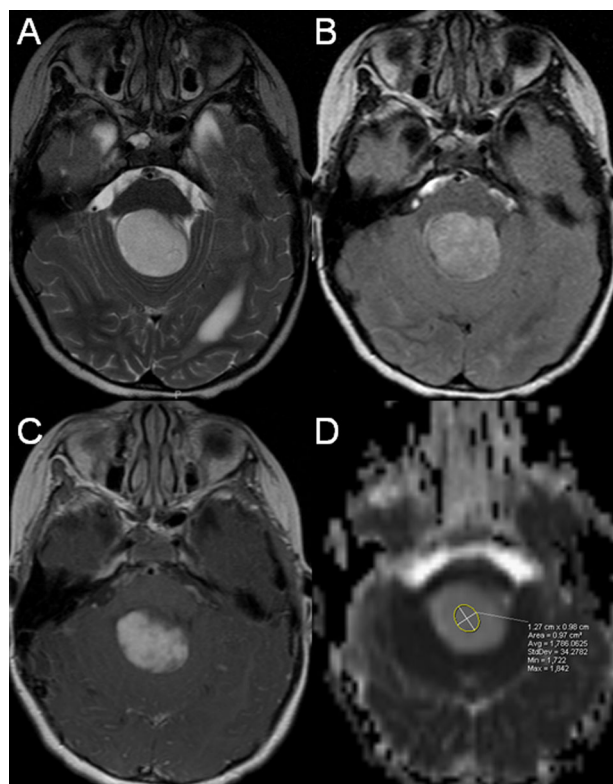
Eleven-year-old female with cerebellar PA. A: Axial T2-weighted and (B) FLAIR images show a large, midline mass with heterogenous, hyperintense signal. No surrounding edema is noted. The fourth ventricle is effaced. C: axial contrast enhanced T1-weighted image at the same level as (A) and (B) reveal a prominent enhancement. D: ADC map corresponding to (A)–(C) reveal matching high ADC-values (hyperintense) compared with normal cerebellar tissue representing increased diffusion.
